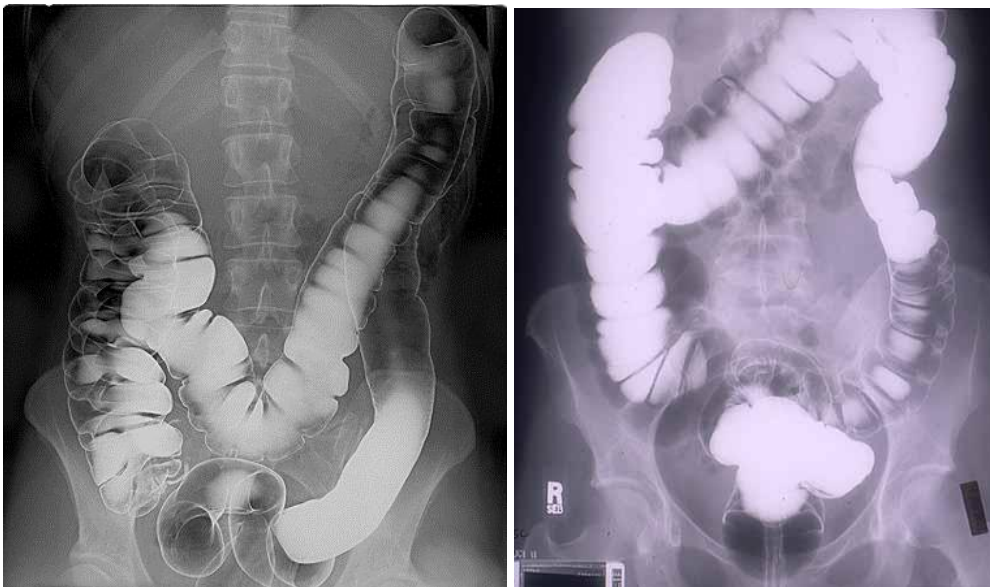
X-ray imaging of barium meal
